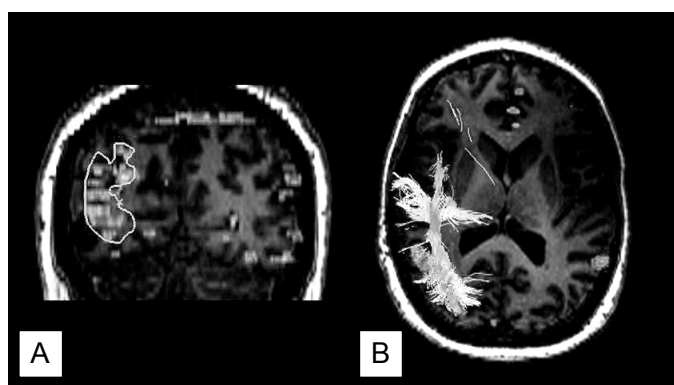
MEG Coherence of spontaneous cortical activity overlaid on the volumetric MRI of Subject # 9. High areas of coherence are lighter colored overlays. A. Coronal view of ROI surrounding high coherence areas in the right temporal lobe. B. Inferior Longitudinal Fasciculus fibers tracked through the single ROI identified from MEG coherence.
